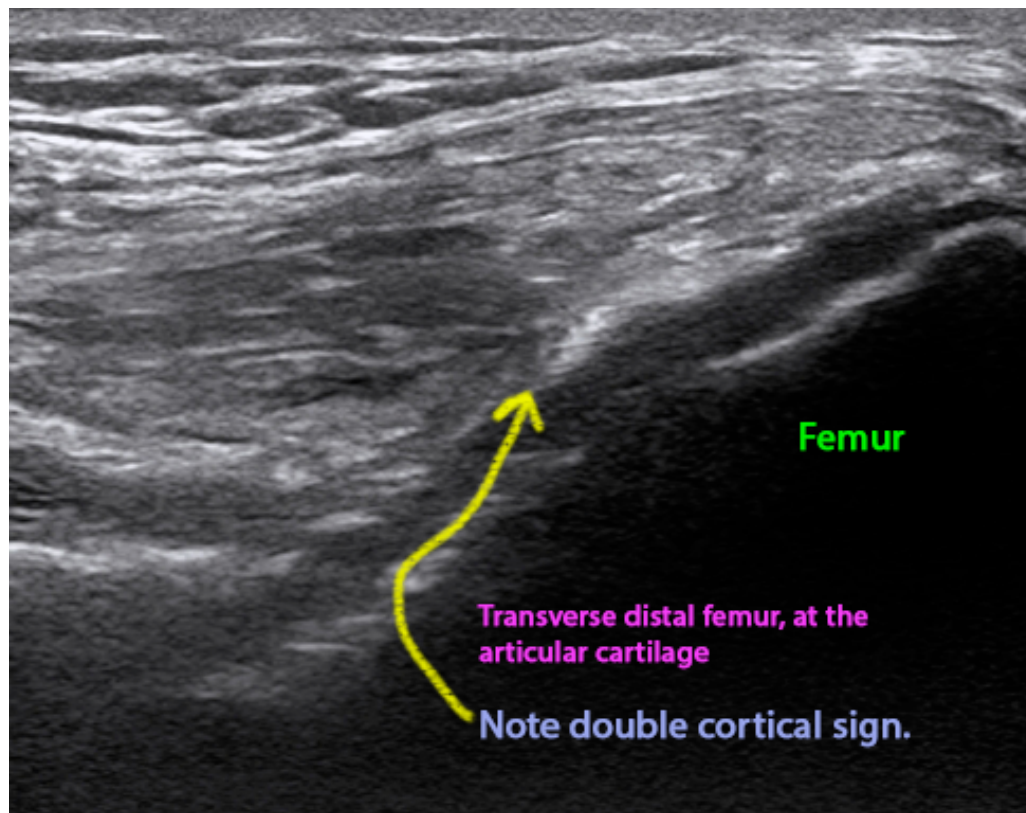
Ultrasound image demonstrating gout induced arthropathy of the knee joint. Note the double cortical sign which is characteristic of crystal arthropathy.
